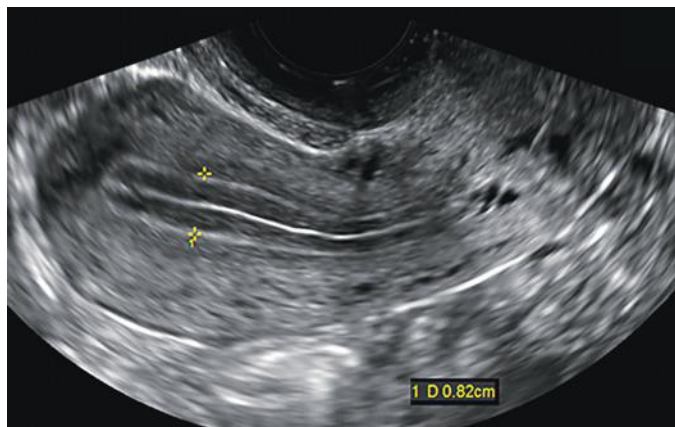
Role of ultrasound in monitoring endometrial changes. Sagittal gray-scale image of the endometrium was obtained during a follicular monitoring examination. The endometrial pattern is multilayered or trilaminar, with an anteroposterior diameter thickness measuring 8 mm (*calipers*), consistent with the periovulatory phase.
